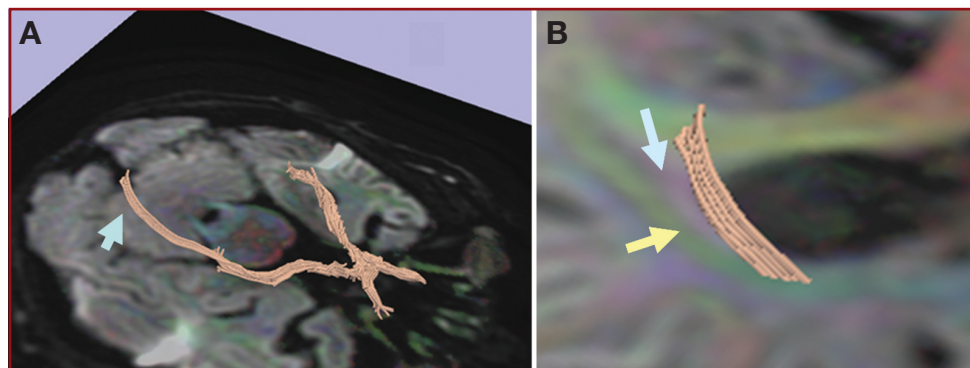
Three-dimensional representation of the visual pathways, reconstructed from the optic nerve to distal fibers of the optic radiation and not including Meyer's loop. The 3-dimensional fibers are overlaid onto a midpontine axial MRI slice depicted in color-by-orientation mode. A, given that the tracts are represented in 3 dimensions, the fibers (arrow) are located in the parietal lobe. These fibers are located in the corona radiata (magnified in B). B, the location of the fibers of the optic radiation in the corona radiata. It can be seen that the reconstructed optic radiation fibers course along a green tract, which, by tractography convention, represents anterior/posterior directionality (yellow arrow). Medially and adjacent to it, with a location between these fibers and the ventricular wall, a tract shown in blue, based on diffusion tensor imaging convention (superior/inferior directionality), can be visualized. This tract likely corresponds to the fibers of the tapetum (blue arrow).
